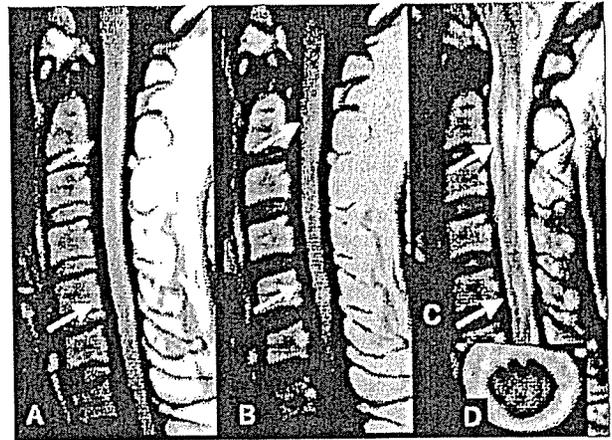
Cervical MRI showed focal swelling (A, arrows) with slight gadolinium enhancement (B, arrows) on T1-weighted imaging. T2-weighted image showed high intensity signals at the same level on sagittal section (C, arrows), which was located at the center of the spinal cord (D, C2 level).
